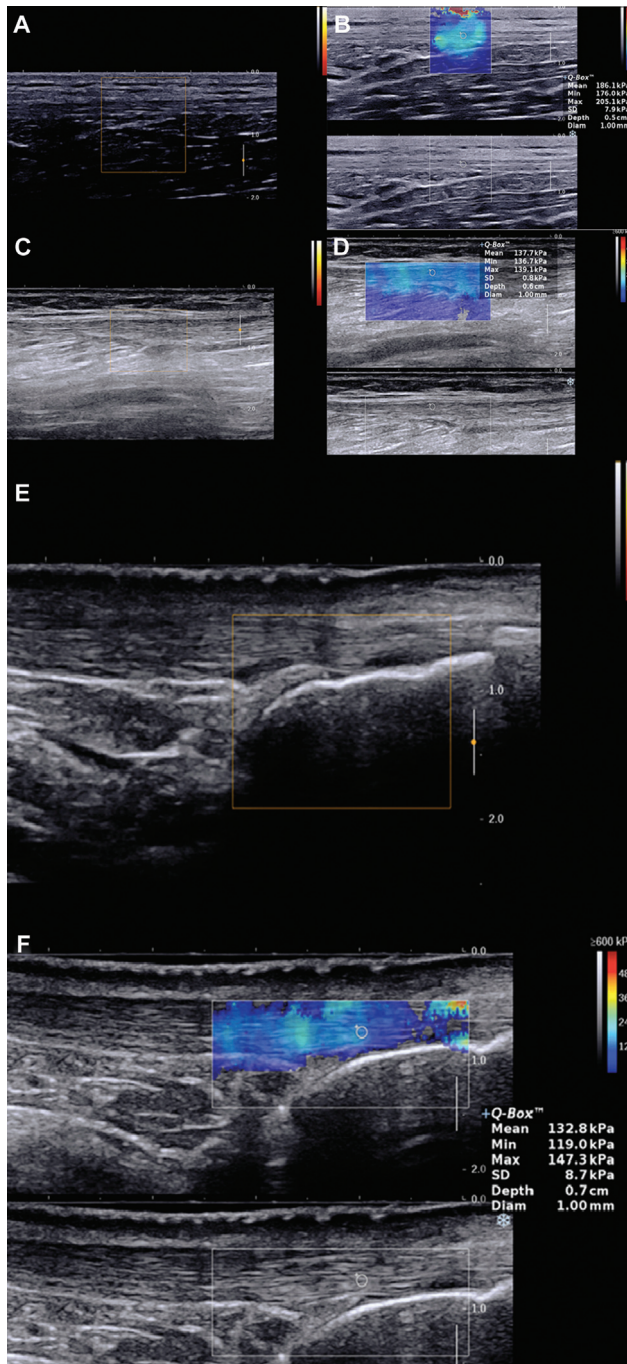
Sagittal gray scale (GS) ultrasound, power Doppler (pD), and shear-wave elastography (SWE) images of the Achilles tendon in patients with psoriatic arthritis (PsA). Dual-screen was used showing GS ultrasound image with an overlying elastogram. Images of the proximal third part of the Achilles tendon; (A) pD image showing no color flow; (B) dual-screen SWE image showing color elastogram with circle representing the region of interest (ROI) where elastic modulus kilopascal (kPa) was measured with mean elastic modulus measuring 186.1kPa. Images of the middle third part of the Achilles tendon; (C) pD image showing no color flow; (D) dual-screen SWE image showing color elastogram with circle ROI where elastic modulus kPa was measured with mean elastic modulus measuring 137.7kPa. Images of the distal third part of the Achilles tendon; (E) pD image showing no color flow; (F) dual-screen SWE image showing color elastogram with circle representing the ROI where elastic modulus kPa was measured with mean elastic modulus measuring 132.8kPa. Color ranges from blue (softer) to red (stiffer).
